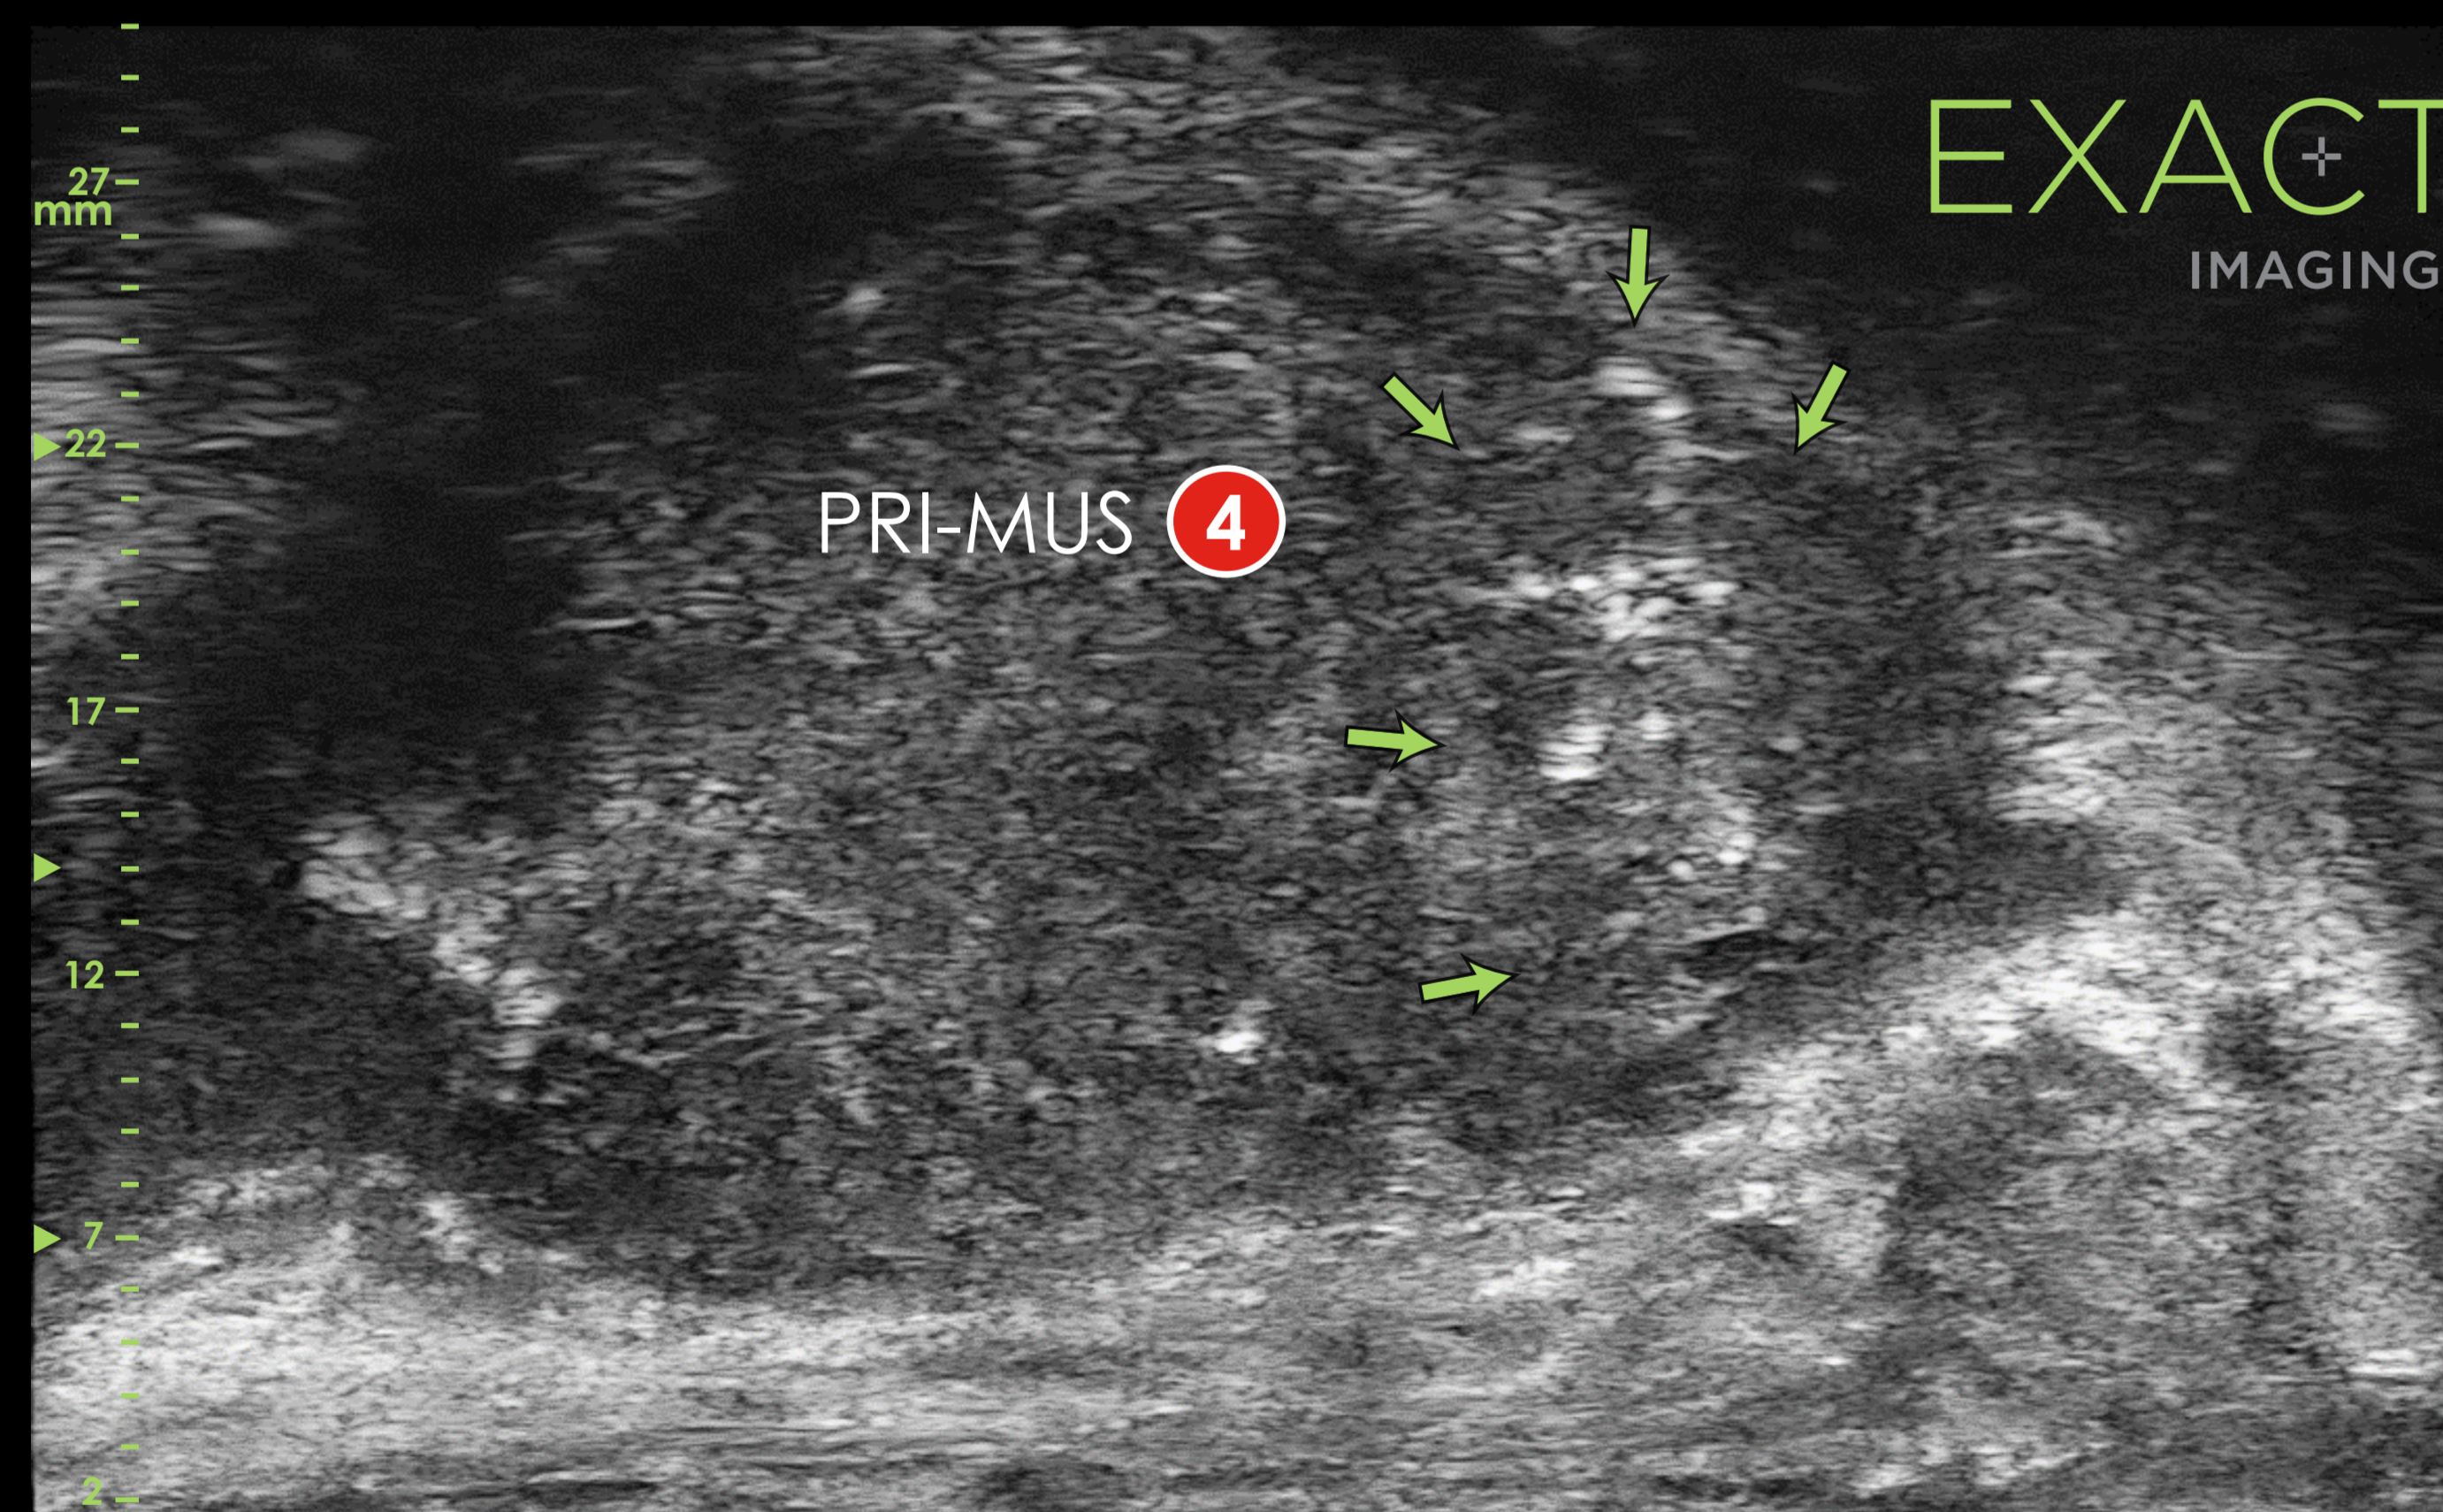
This is a micro-ultrasound image of a PRI-MUS 4 lesion (suspicious target with "Starry Sky" appearance). This core was positive on Pathology (GS 7).
